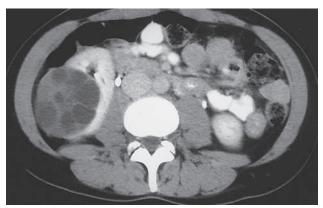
Solitary multilocular cyst. Contrast-enhanced CT shows a solitary, septated, and well-circumscribed renal cystic lesion in the right kidney.
